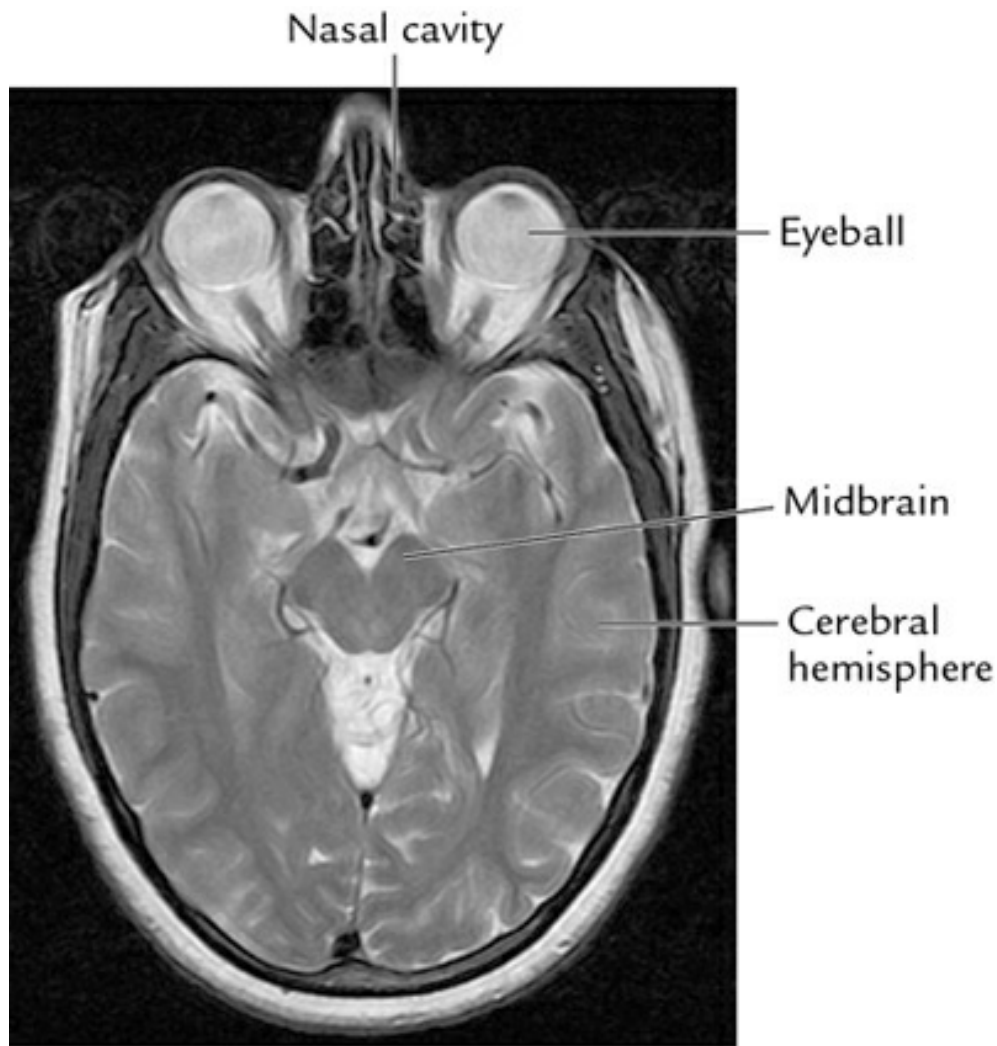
■ MRI of the head. (*MRI*, magnetic resonance imaging.)
